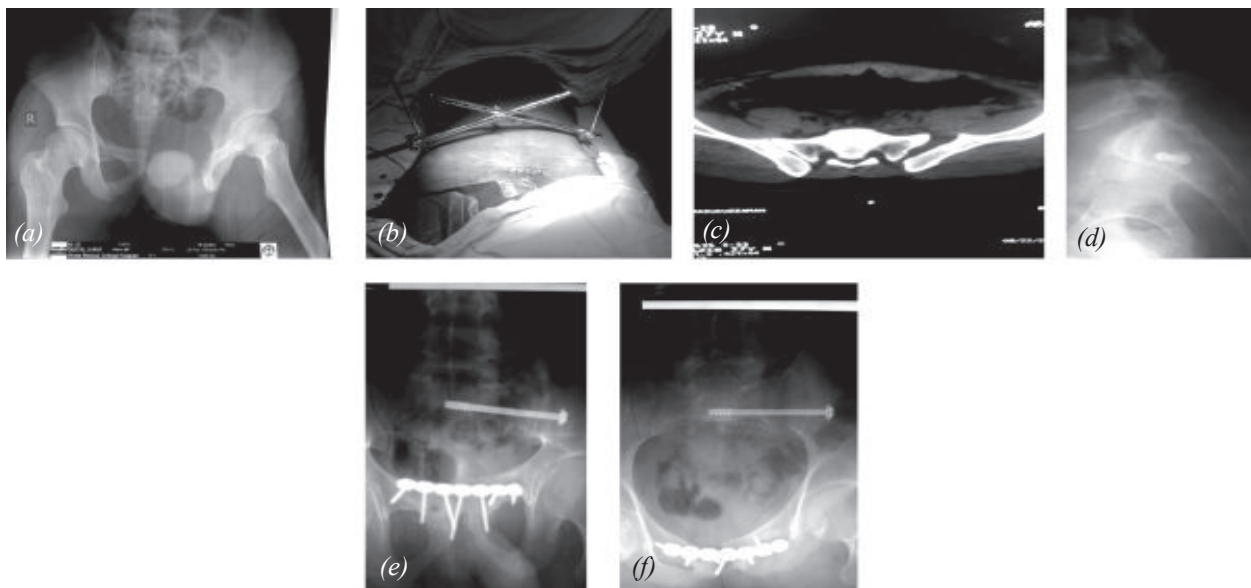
(a) Pre-operative X-ray. Tiles type B1 fracture. (b) Pt. with external fixator before operation (c) pre-operative CT scan (d) Post operative lateral view x-ray (e) Post operative outlet view x-ray (f) Post-operative inlet view x-ray.
